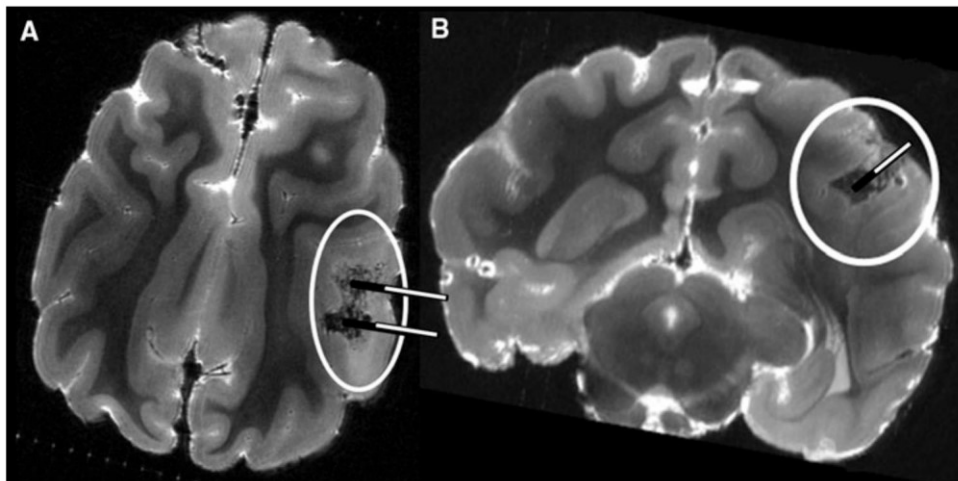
ex vivo* high-resolution 7.0 T MRI of NTIRE treated brain <sup>103</sup>
